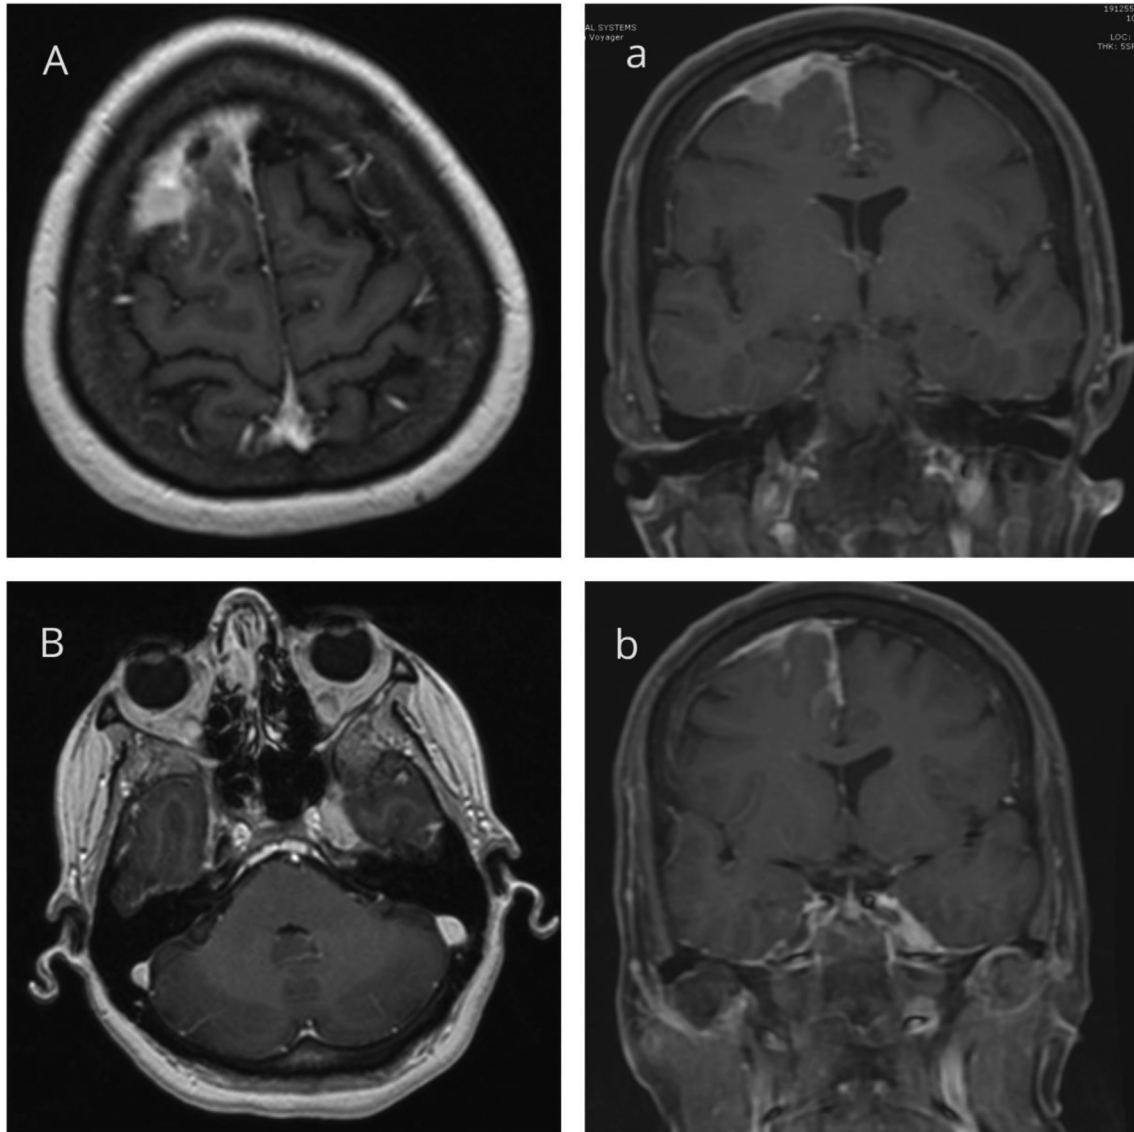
Pre-op MRI of the patient in different planes and sections-coronal and axial T1-weighted film with gadolinium showing the convexity lesion (A, a), coronal and axial T1-weighted film with gadolinium showing the cavernous lesion (B, b).
